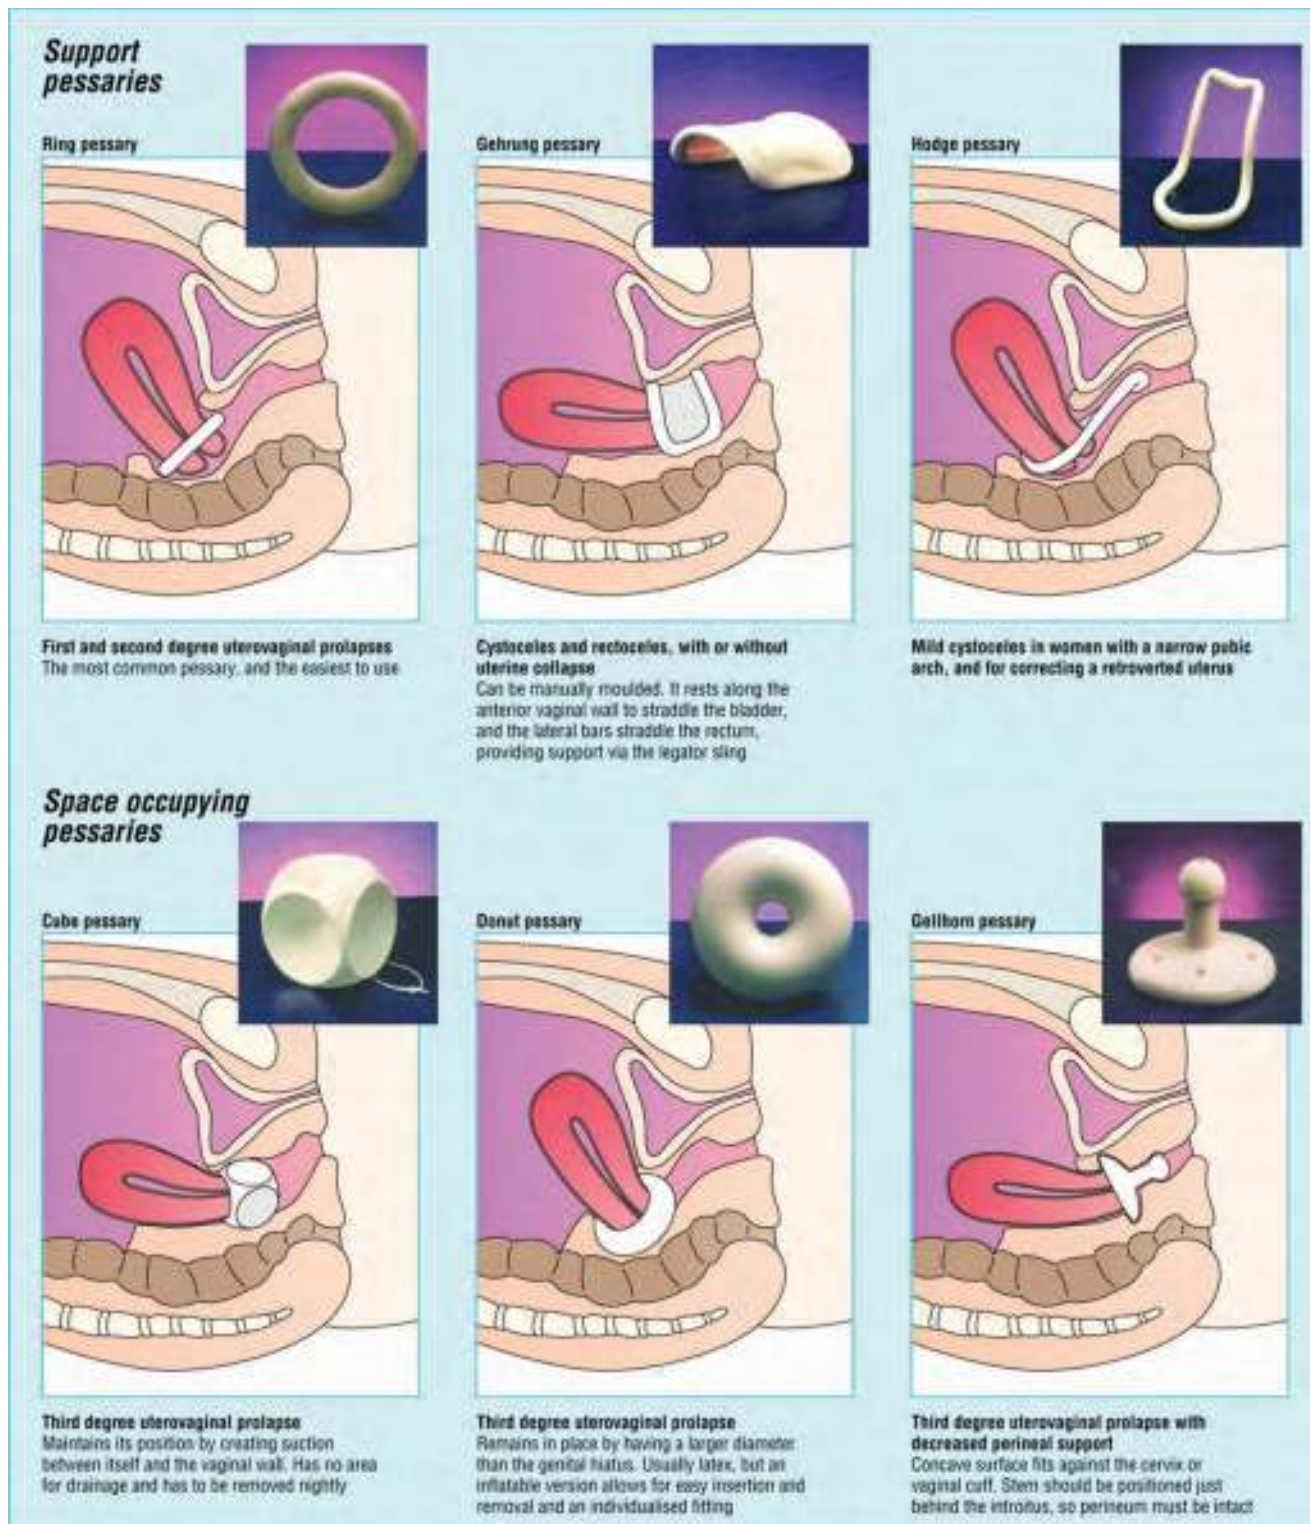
The use of different types of pessaries. (Photo courtesy of Cooper Surgical, Inc., Trumbull, CT.)
